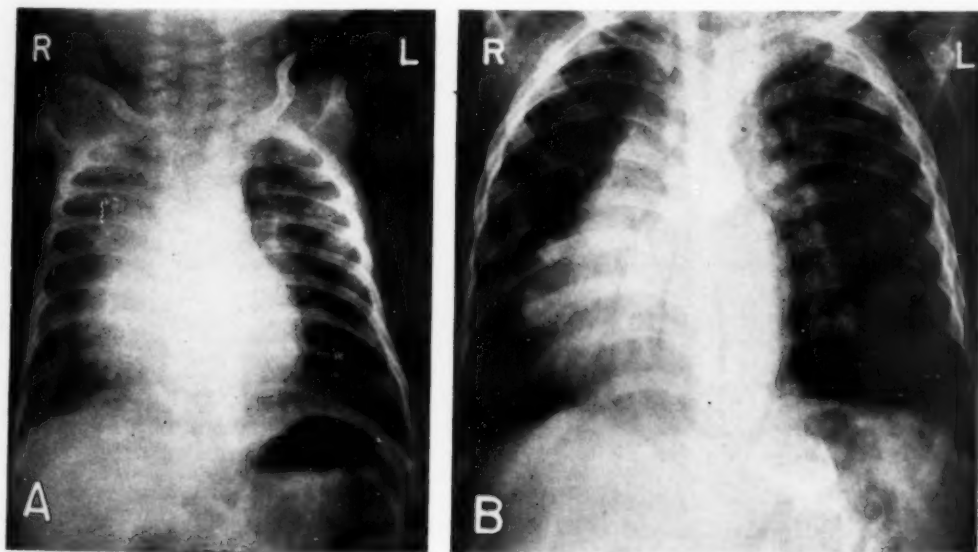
Case VII. Postero-anterior roentgenograms. A. At birth. B. At two years. Enlarged right-sided heart and pulmonary over-circulation. Left diaphragm slightly higher than right. Note normal situs of abdominal viscera.
